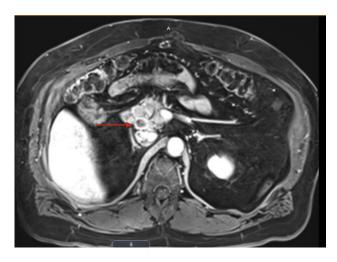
Surveillance magnetic resonance image demonstrating recurrence of intraductal papillary neoplasm from the remnant bile duct.
